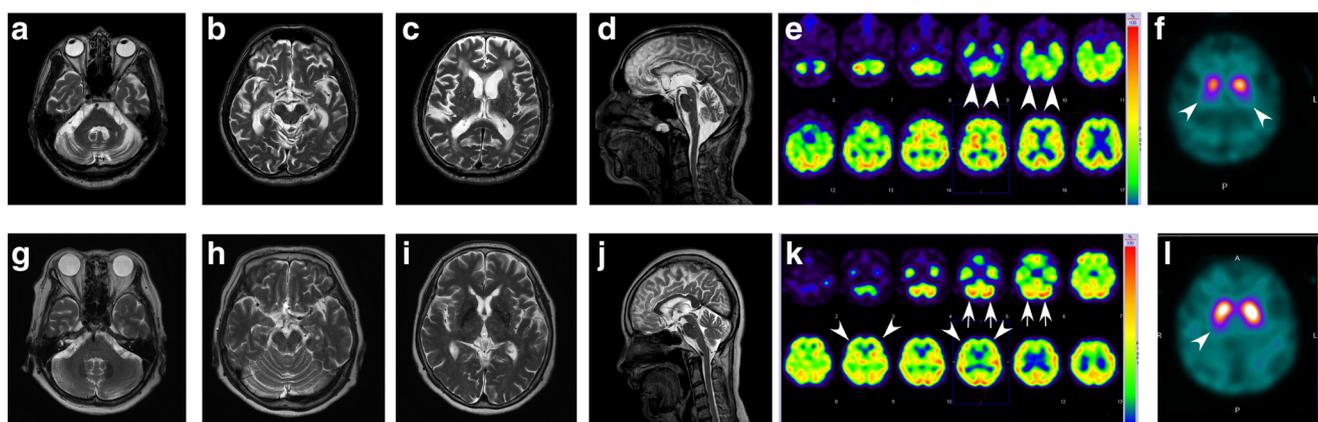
The result of imaging in a patient who had PSP with 131 combined repeats (a–f) and a patient who had ataxia with intermediate (74) repeats (g–l). a–d Brain MRI T2-weighted imaging (GE, SIGNA 3T, TE/TR = 80/4000 [a sagittal image] and TE/TR = 100/5661.07 [axial images]) showed modest cerebellar atrophy and mild atrophy of the midbrain and the frontal lobes with multiple ischemic changes in the white matter, the basal ganglia, and the brainstem. e IMP-SPECT revealed decreased perfusion in the cerebellum (arrowhead). f Dopamine transporter imaging using ^{123}I -ioflupane revealed severely reduced tracer uptake in bilateral
